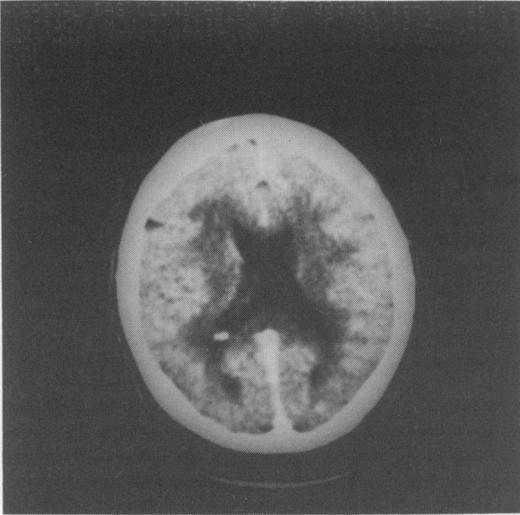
CT shows periventricular leuko-araiosis in fronto-parietal areas suggesting demyelination.
